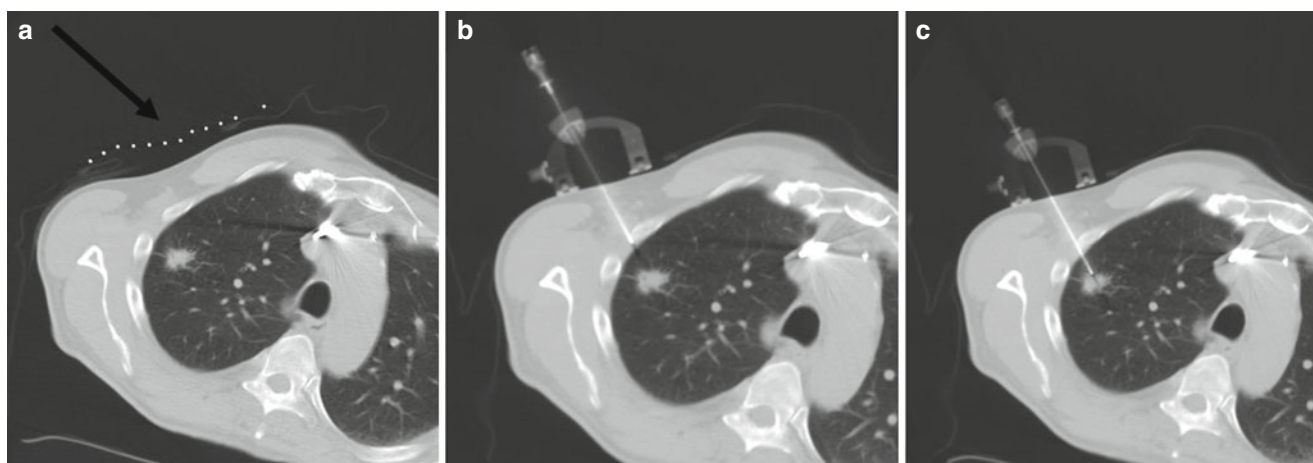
Representative images during percutaneous lung biopsy using the Simplify (NeoRad, Oslo, Norway). (a) Grid placement and initial CT scan confirms right upper lobe lung nodule for biopsy. A grid is placed on the overlying skin to mark the target at the level of the skin
